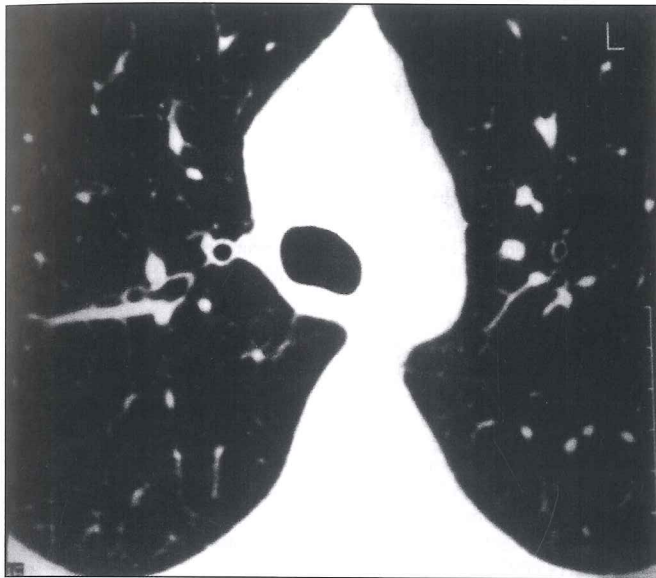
HRCT images of a control subject (A), a patient with a mild asthma (B), a patient with moderate asthma (C) and of a patient with a history of near fatal asthma (D).
